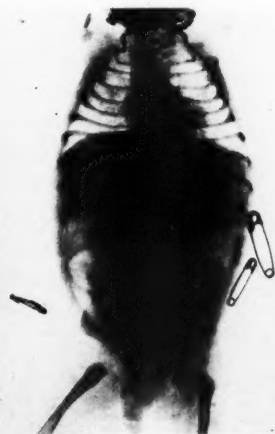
This plain film shows large gas pockets in the bowel of an infant two days old.
